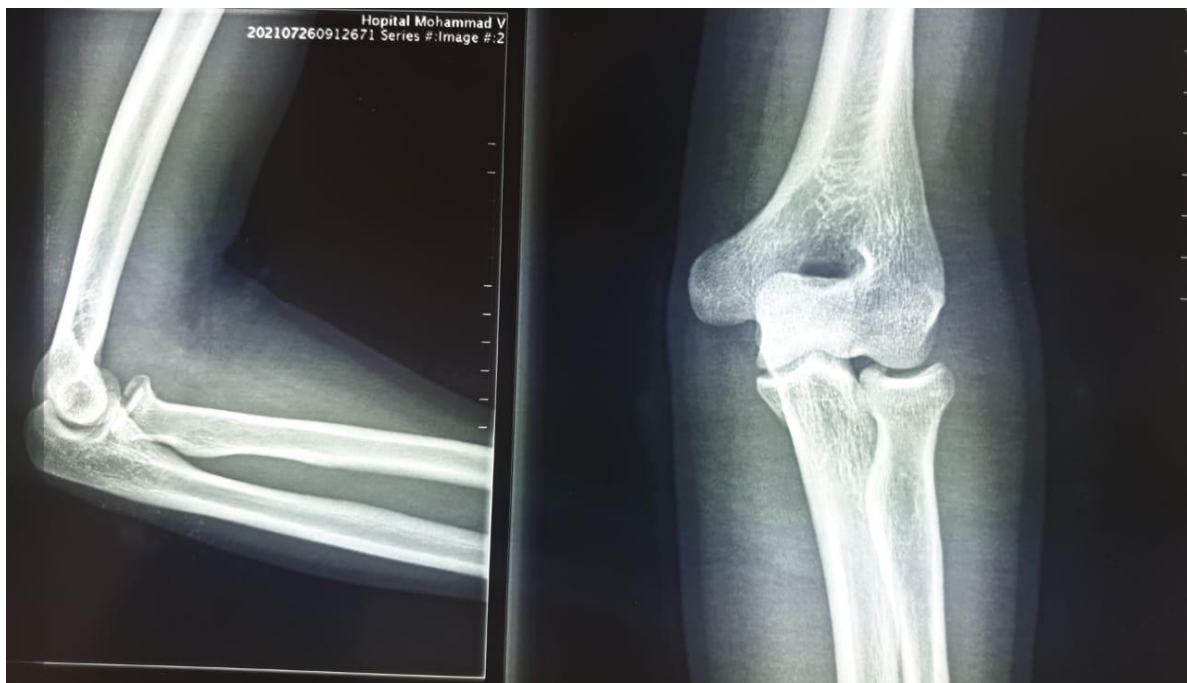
Front X-ray of Left elbow, face and profile showing mason I radial head fracture.
